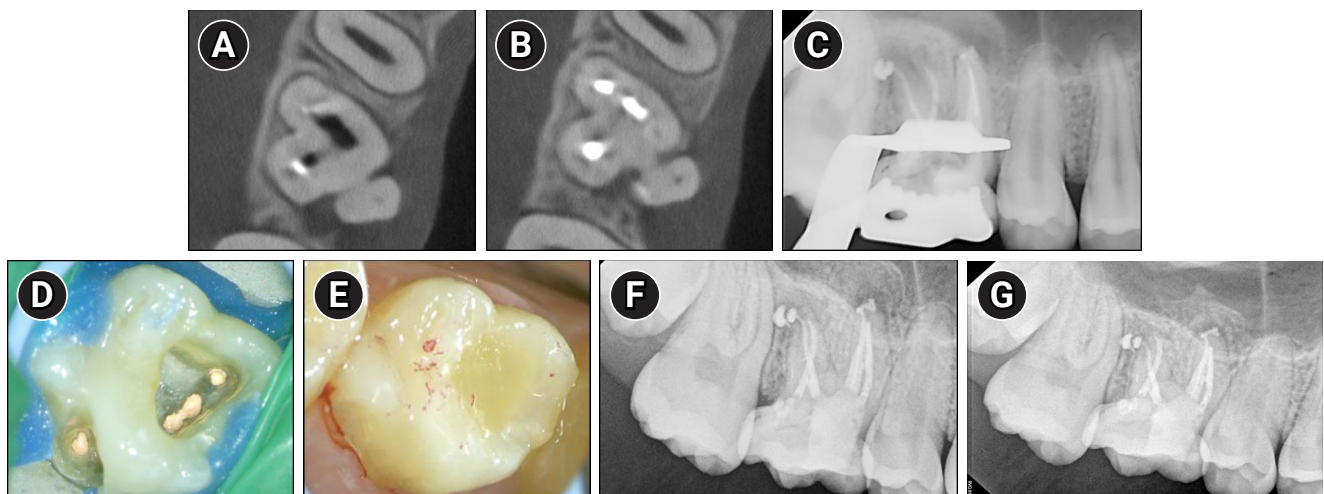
Identification and treatment of the palatal canal through buccal access in maxillary right first molar (#16). (A, B) Retaken cone-beam computed tomography axial views showing the palatal canal located more mesially than initially anticipated. (C) Radiograph taken after obturation of the palatal canal. (D) Clinical view of the completed obturation including the palatal canal. (E) Clinical view of the core buildup, demonstrating proper occlusal contacts. (F) One-month follow-up radiographs demonstrating reduction of the periapical radiolucency. (G) Five-month follow-up radiographs showing a further reduction of the periapical radiolucency.
